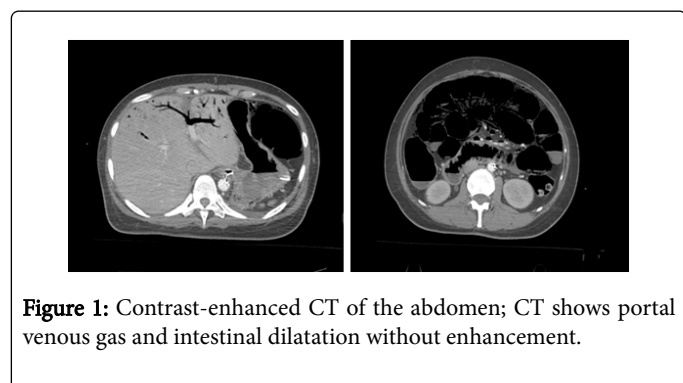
Contrast-enhanced CT of the abdomen; CT shows portal venous gas and intestinal dilatation without enhancement.
